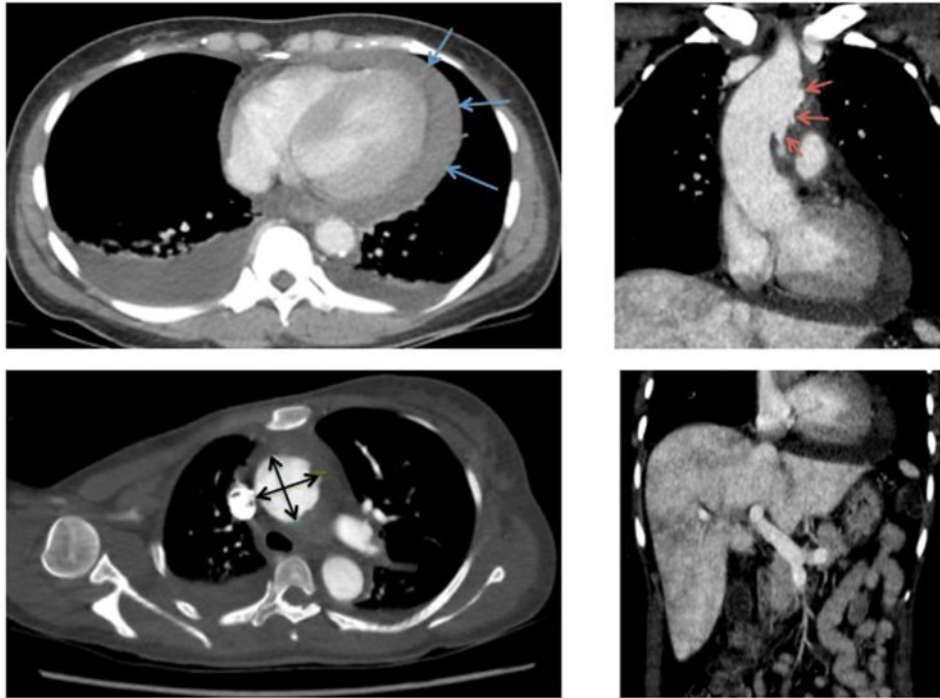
Different views on computed tomography aortogram showing features of aortic dissection with end-organ malperfusion. (A) An ulcerated ascending aorta dilatation up to 4.3 cm with unilateral pleural effusion. (B) A long segment of irregular, eccentric intramural haematoma along ascending aorta to aortic arch. (C) Hypoperfusion of liver: hypoenhancement of liver noted. AA, ascending aorta; AR, aortic arch; DA, descending aorta; PA, Pulmonary artery.
